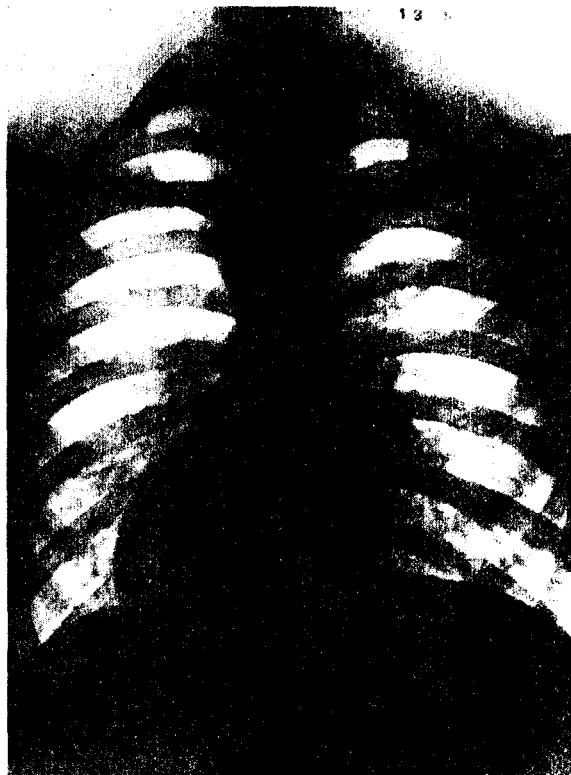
Roentgenogram of the chest, nearly 5 months after Fig. 1.
